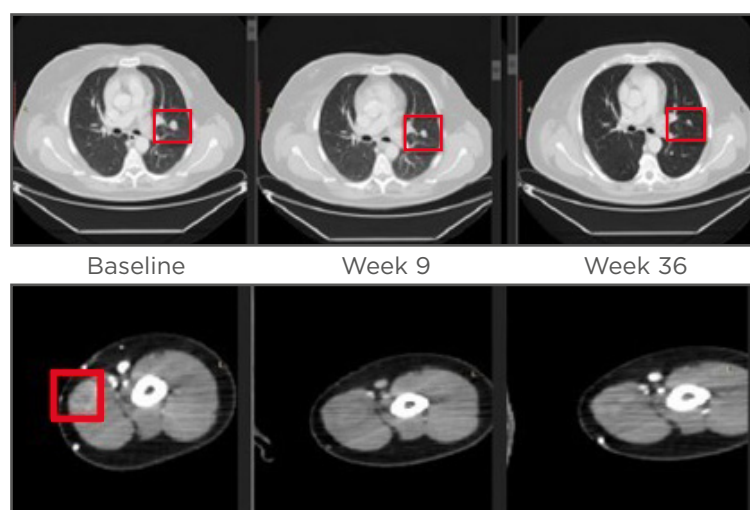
Axial CT images of left upper lobe lung lesion and subcutaneous left bicep lesion.
